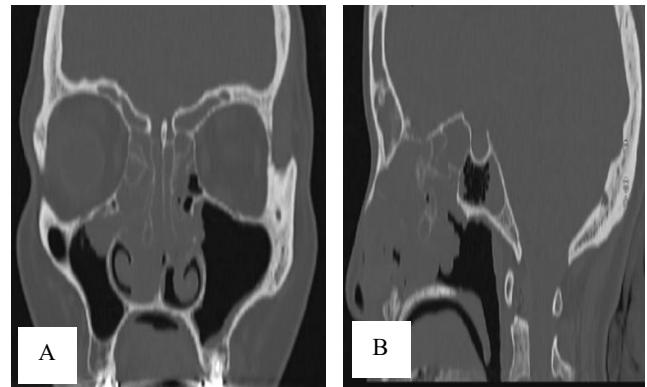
(A) plain computed tomography of paranasal sinuses coronal section: showing homogenous soft tissue opacification involving both nasal cavities with widened olfactory cleft and (B): plain computed tomography of paranasal sinuses sagittal section: showing homogenous soft tissue opacification involving nasal cavities with widened olfactory cleft.
